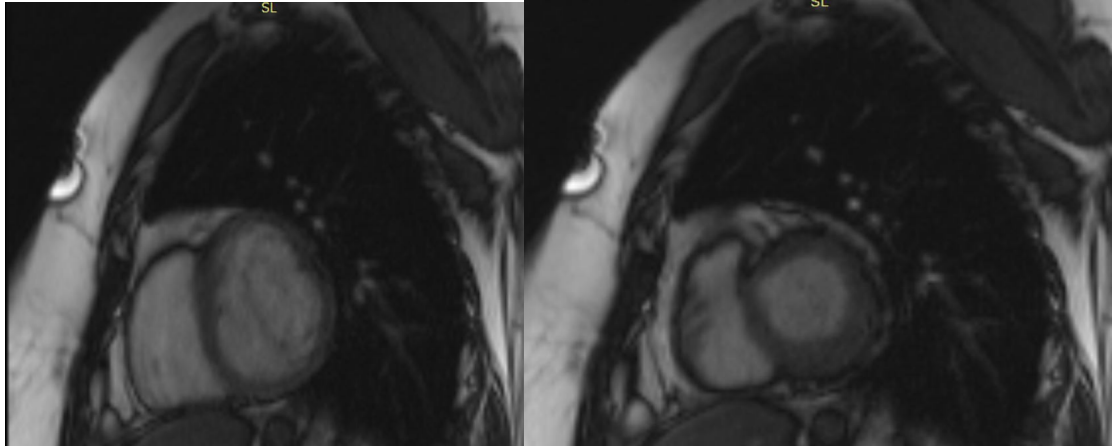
Short axis view of cardiac MRI revealing a LVNC (diastolic and systolic).
